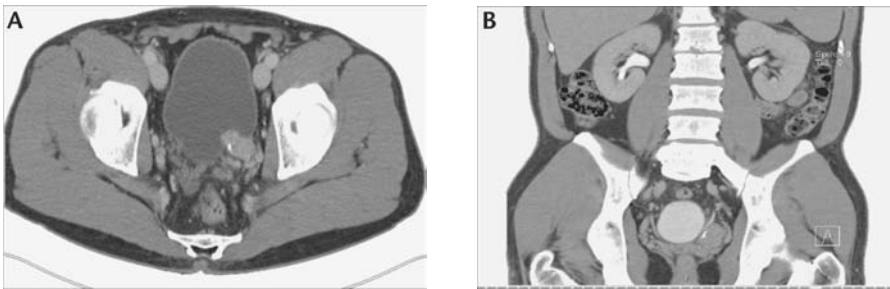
Computed tomographic urogram revealing (A) a well-circumscribed, lobulated soft tissue mass measuring 3×2 cm adjacent to the insertion of the ureter at the left ureterovesical junction with no evidence of ureteral obstruction and (B) sagittal reconstruction revealing the perivesical mass with focal calcification.
